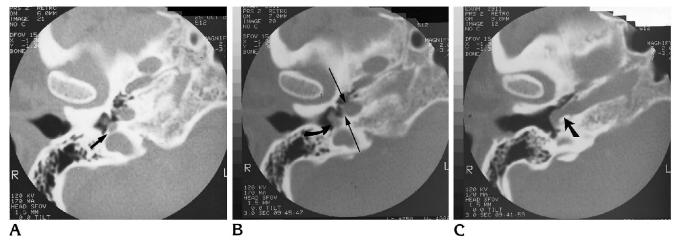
A*, Axial CT scan shows a large inferior tympanic canaliculus interposed between the carotid and jugular foramina (*arrow*). *B*, Axial CT scan just superior to *A* shows dehiscence of the anterolateral wall of the aberrant carotid canal (*curved arrow*). Note the adjacent soft-tissue mass within the hypotympanum. *Straight arrows* show the normal carotid canal.
